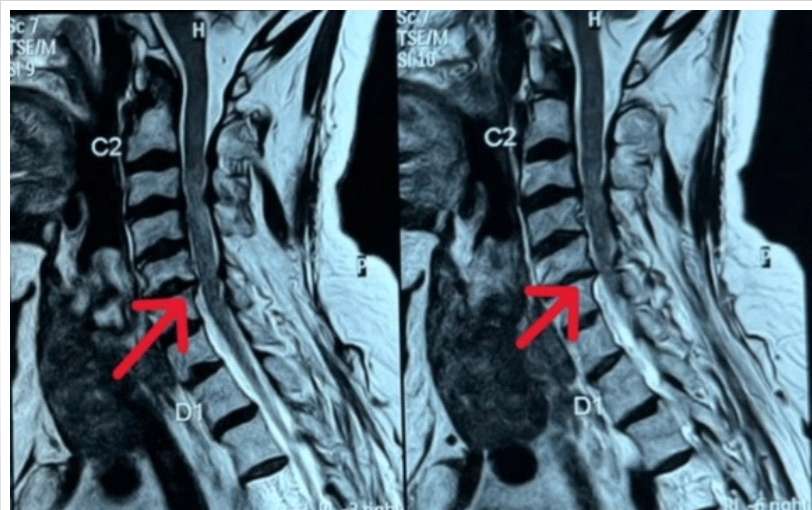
Preoperative sagittal T2-weighted magnetic resonance image of the cervical spine. Mid-sagittal T2-weighted MRI demonstrating severe spinal canal stenosis and spinal cord compression at the C5–C6 level, with focal intramedullary T2 hyperintensity consistent with chronic compressive myelopathy (arrows)
